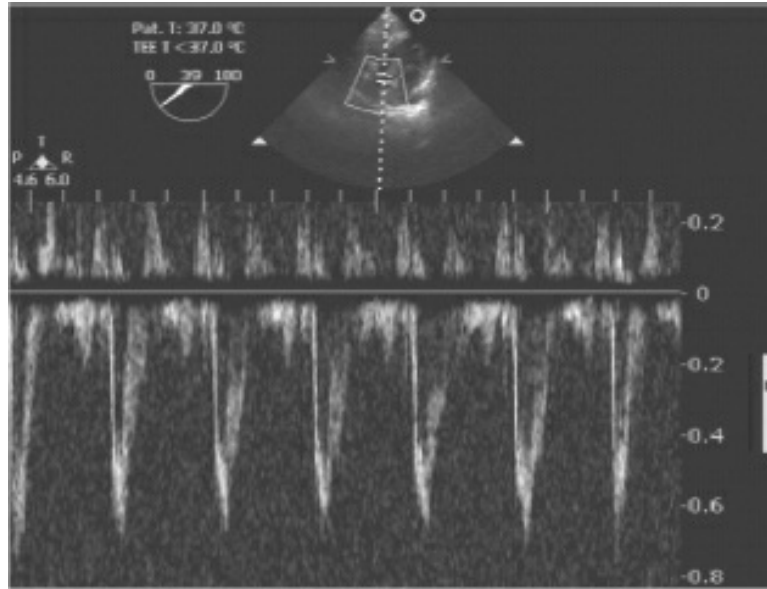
Pulsed Doppler flow across the normal aortic valve in deep trans-gastric view
